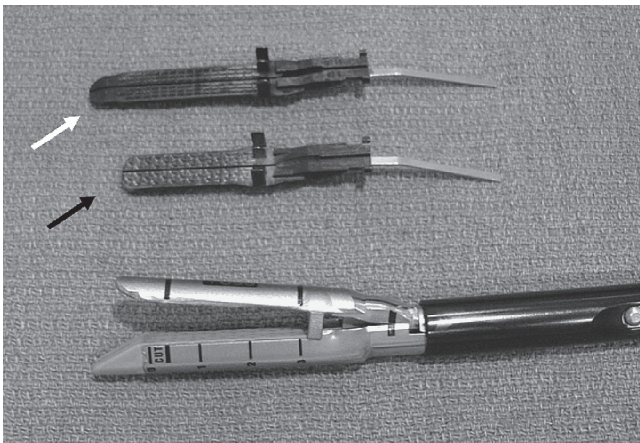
■ The modified Endo GIA 30 stapler (U.S. Surgical Corp., Norwalk, CT). The anvil is modified by shortening the tip to allow the staple to go to the base of the septum. The *white arrow* indicates an unmodified anvil. The *black arrow* indicates an anvil modified by removal of the tapered end. (From Morse CR, Fernando HC, Ferson PF, et al: Preliminary experience by a thoracic service with endoscopic transoral stapling of cervical [Zenker’s] diverticulum. *J Gastrointest Surg* 11:1091–1094, 2007. Used with permission, Springer Verlag.)
